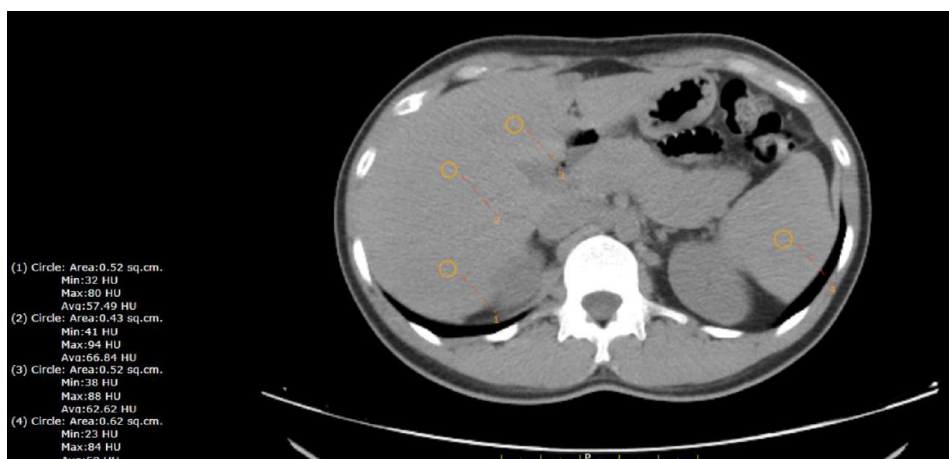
CT-LAI of this candidate was +5HU
